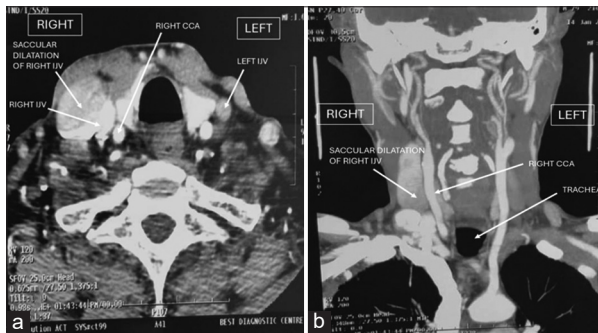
(a) Computed tomography (CT) angiography image showing the saccular dilatation of the right internal jugular vein (axial view) (b) CT angiography image showing the saccular dilatation of the right internal jugular vein (coronal view)
